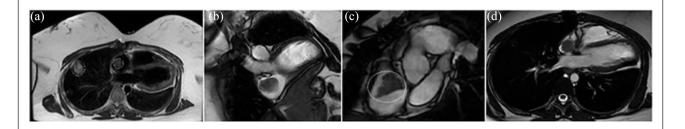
Cardiac magnetic resonance imaging (cMRI) series: (a) Transverse section with left circle encapsulating pleural and lung metastases and center circle encapsulating the right atrial thrombus, (b) coronal section with white circle enveloping the large right atrial thrombus also demonstrating its heterogeneous appearance, (c) sagittal section with white circle enveloping the large right atrial thrombus again demonstrating its heterogeneous appearance, and (d) transverse section indicating the encircled pedunculated heterogeneous thrombus attached by a stalk from the right atrial free wall.
